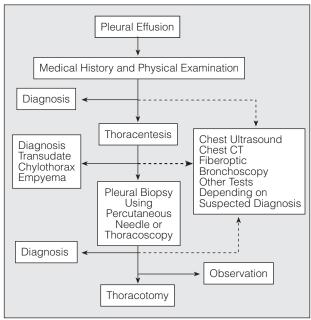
General diagnostic algorithm for patients with pleural effusion. CT indicates computed tomography.
